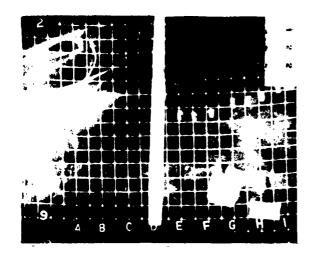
X-ray Location of Implant.
